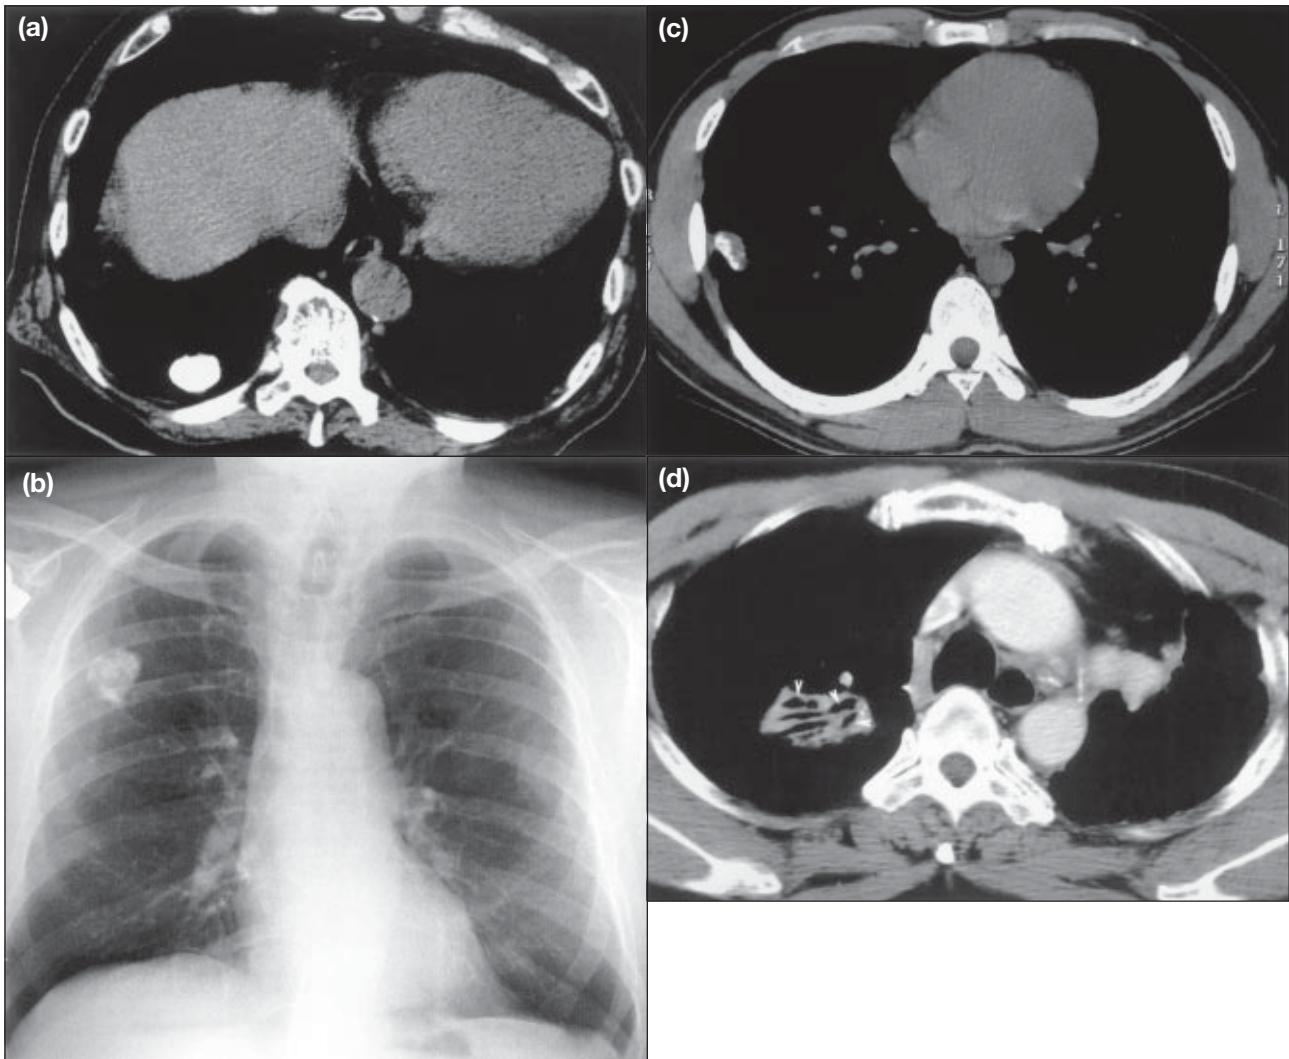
Computed tomograms and X-rays of a solitary pulmonary nodule
